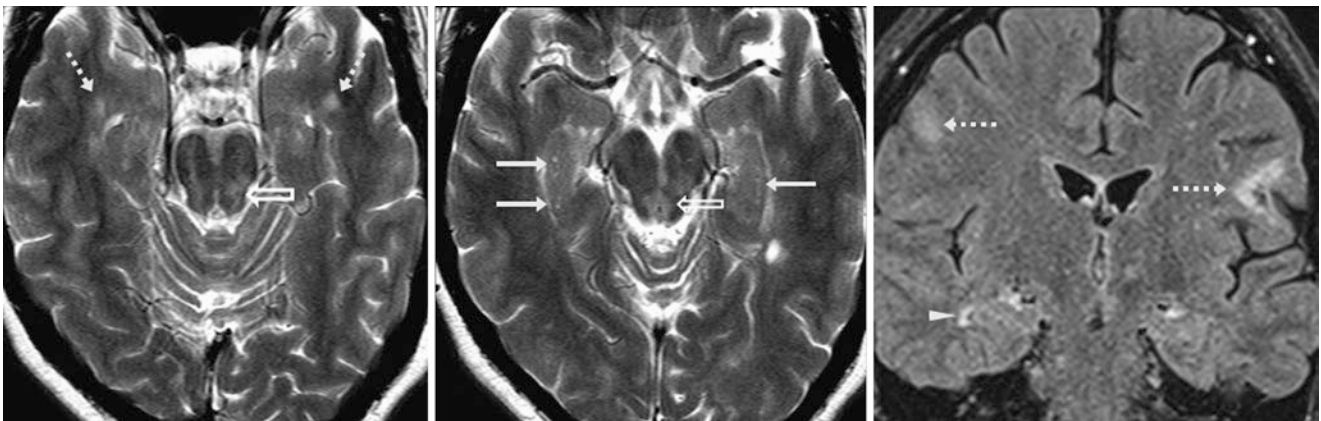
Comparison case of multiple sclerosis. On axial T2WI (*left and middle*), a 32 year old had bilateral temporal plaques (*dotted arrows*). Note and compare to normal hippocampal cysts (*arrows*). Coronal FLAIR (*right*) shows other plaques, such as a right temporal plaque (*arrowhead*); also note midbrain lesions (*open arrows*)
